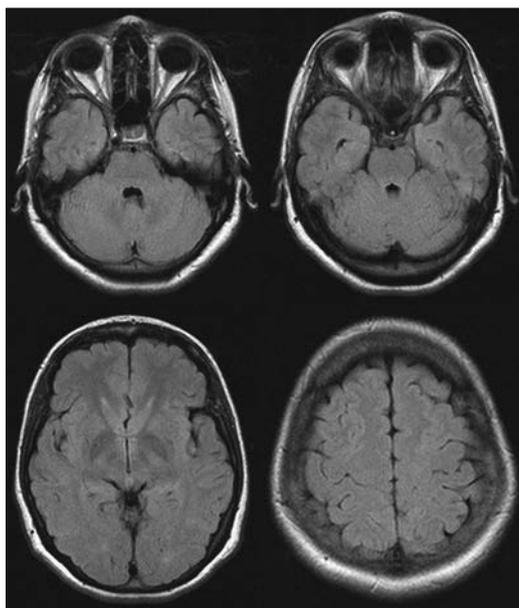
Follow-up MRI 3 months after treatment demonstrates complete resolution of the pathological signal alterations on transverse FLAIR images. Diffusion-weighted MR imaging and apparent diffusion coefficient mapping (*not shown*) revealed no pathological findings.
